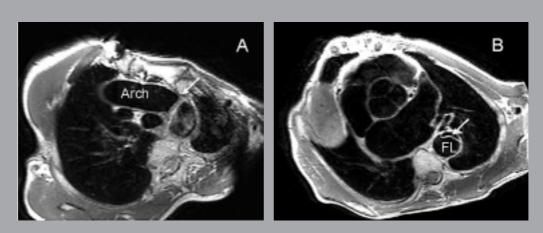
A and B: oblique transverse proton density-weighted magnetic resonance images obtained with cardiac-gated double inversion recovery fast spin-echo sequence at different levels through the thorax. The dissection (arrow) begins at the last segment of the aortic arch (Arch); at a more caudal level it may be seen that the false lumen (FL) is much larger than the true one.
